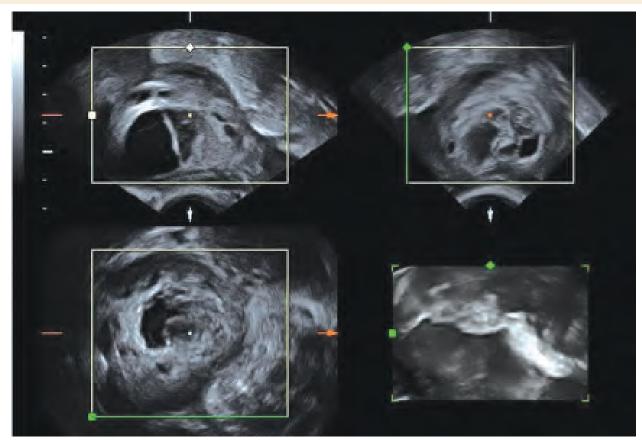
Transvaginal three-dimensional ultrasound image of an early corpus luteum. Blood filled cavity of the former follicle is clearly visualized on three orthogonal planes
